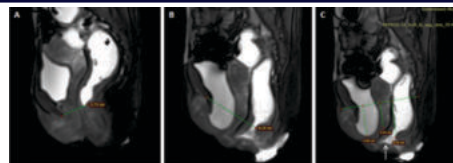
Mid sagittal FIESTA MR image at rest (A), the M line is mildly elongated (3.7 cm) and at maximal defecation (B), there is caudal descent of the pelvic floor, with the M line increasing to 8.2 cm; Mid sagittal FIESTA MR image obtained at maximal defecation (C) shows a cystocele (4.8cm), moderate vaginal/cervical prolapse (4.0cm), rectal prolapse (5.7cm) and small anterior rectocele (arrow).
